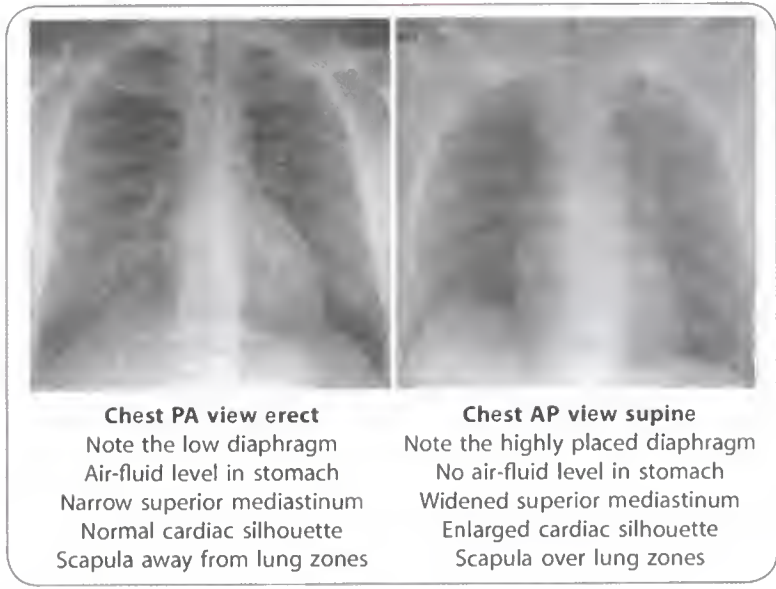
Chest X-ray for demonstrating effects of various patient positioning
